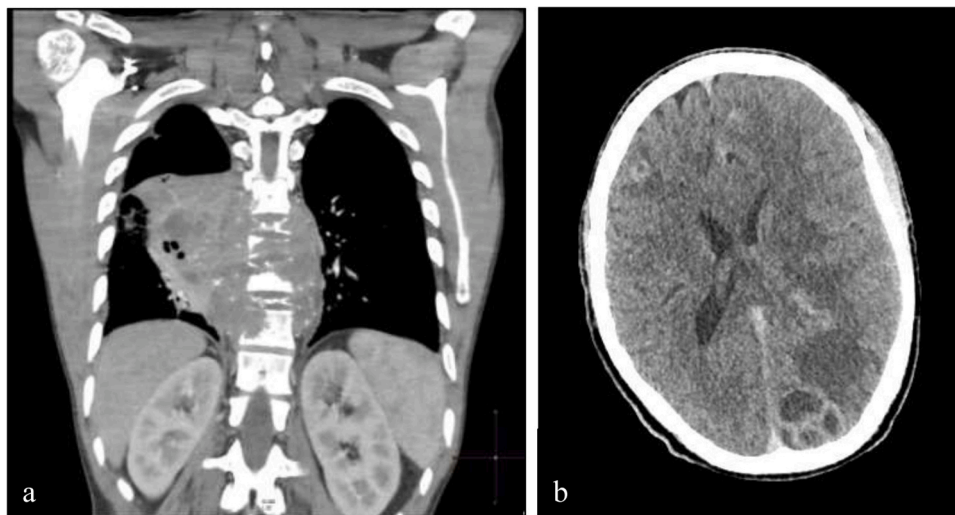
Computed tomogram (CT) of the chest (a) and brain (b). Fig. 2a: CT chest, coronal reconstruction, demonstrating a paravertebral collection extending into the apex of the right lower lobe with dense consolidation, cavitation and pulmonary nodules. Bilateral pleural effusions and extensive lymphadenopathy (not shown) were present. Fig. 2b: Post contrast CT of the brain shows multiple abscesses with surrounding oedema in bilateral hemispheres, the midbrain and pons.
